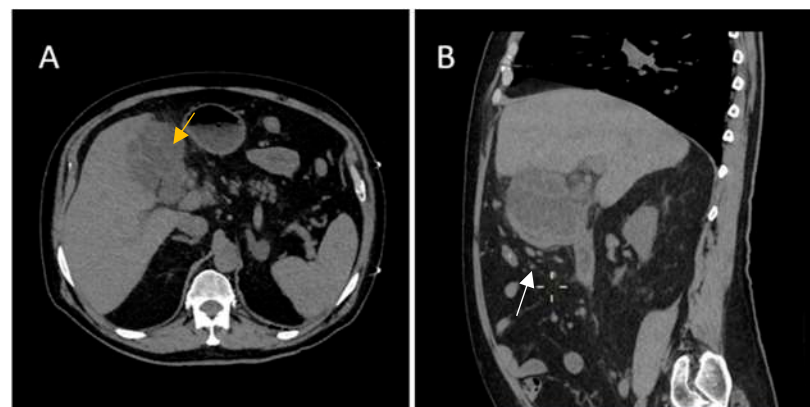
A 70-year-old male with a history of hypertension, type 2 diabetes, peripheral venous thrombosis, presented at our Emergency Department with abdominal pain accompanied by diarrhea, night sweats and fever. His laboratory findings showed elevated inflammatory markers. Computerized tomography (CT) revealed (B)—diffuse wall thickening with intramural low-density nodules and bands in thickened walls (white arrow) associated with (A) pericholecystic inflammatory change (yellow arrow).
